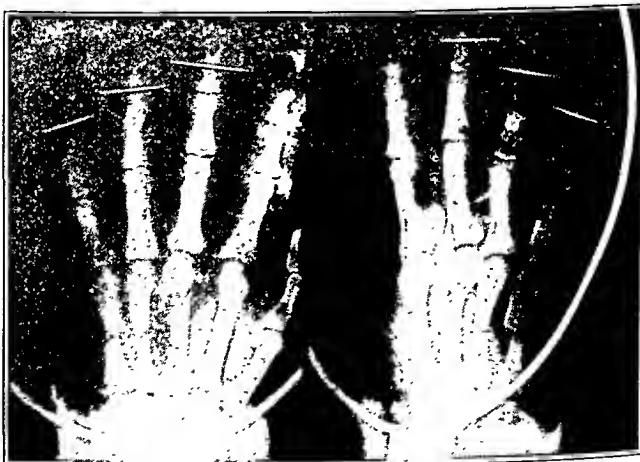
Roentgenogram showing the reduction obtained by the method described. Note the needles through the terminal portions of the phalanges of the third, fourth and fifth fingers. (Published through the courtesy of Dr. John J. Moorhead.)
